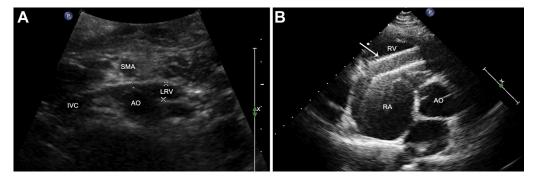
Ultrasonography showing stent migration. (A) Transabdominal ultrasonography showing the absence of the stent in the left renal vein. (B) Transthoracic
